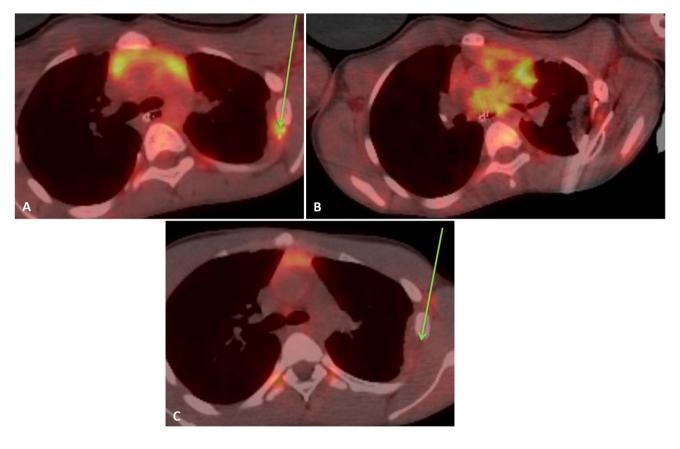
Positron emission tomography (PET)/computed tomography (CT) of a 14-year-old male with a history of recurrent left chest wall desmoid tumor who presented with pain. Pre-procedure PET/CT demonstrated abnormal fluorodeoxyglucose uptake in the left chest wall (green arrow) (A), PET/CT guided placement of cryoablation
